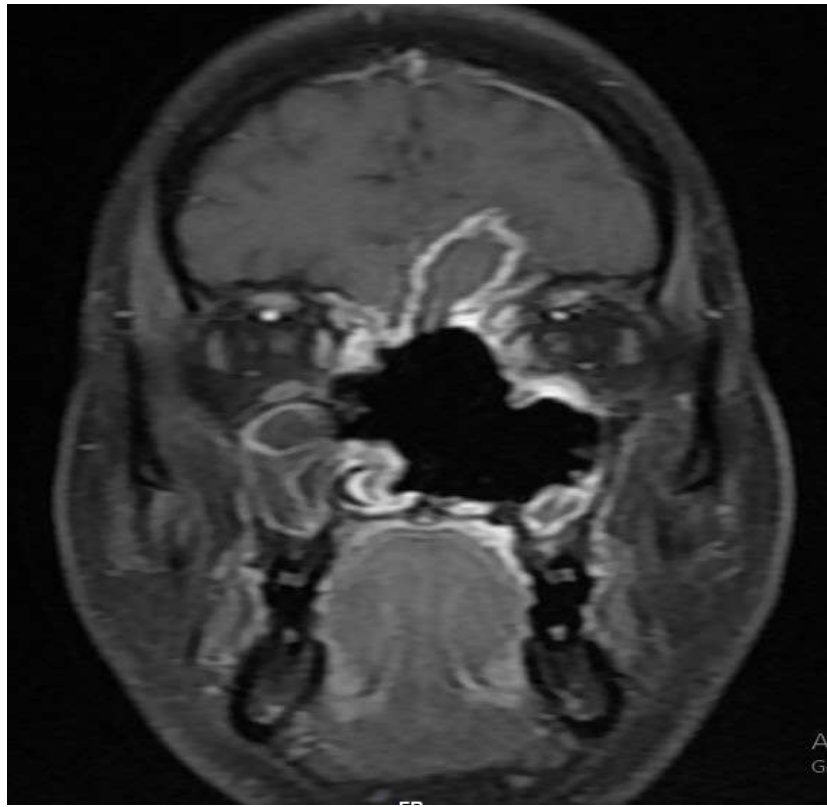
MRI image showing status post functional endoscopic sinus surgery - coronal post contrast T1WI
